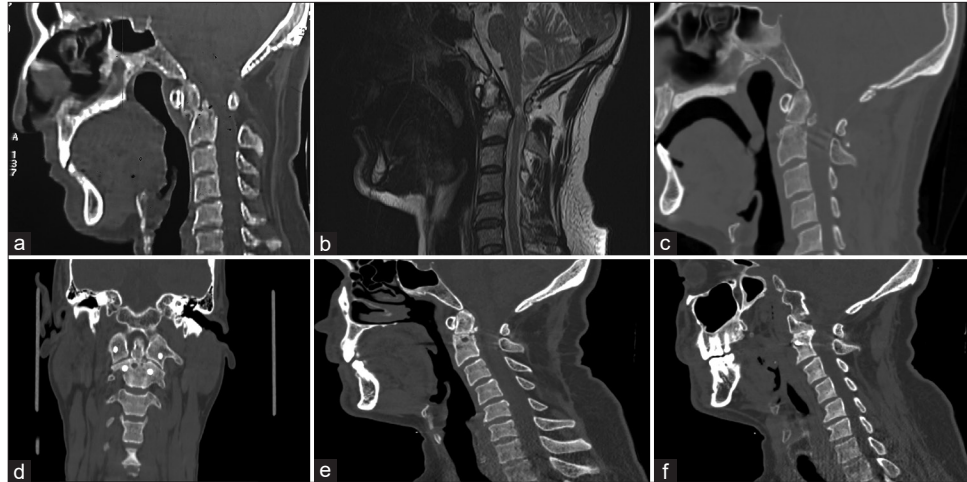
A 60-year-old male with a history of bike accident 7 year ago presented on a wheel chair with a history of progressive weakness and numbness in all four limbs for the past 6 months. (a and b) Preoperative CT and MRI shows old type 2 odontoid fracture with anterolisthesis of C1/odontoid complex on C2 body and some bony fusion with significant cord compression and signal changes. (c and d) Sagittal and coronal CT scan taken in the immediate postoperative period showing alignment of the released odontoid. (e and f) Sagittal and parasagittal CT cuts taken at 1-year postoperative show that the alignment is maintained.
